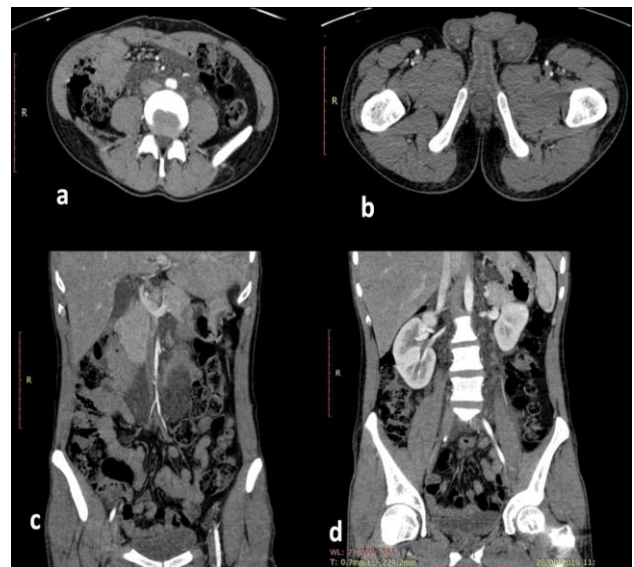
(a) CT scan of abdomen and pelvis in venous phase, axial reconstruction shows non-enhancing retroperitoneal cystic lesion in pre and paraaortic region, (b) bilateral inguinal region (c, d) coronal images showing lesion in retroperitoneum.
